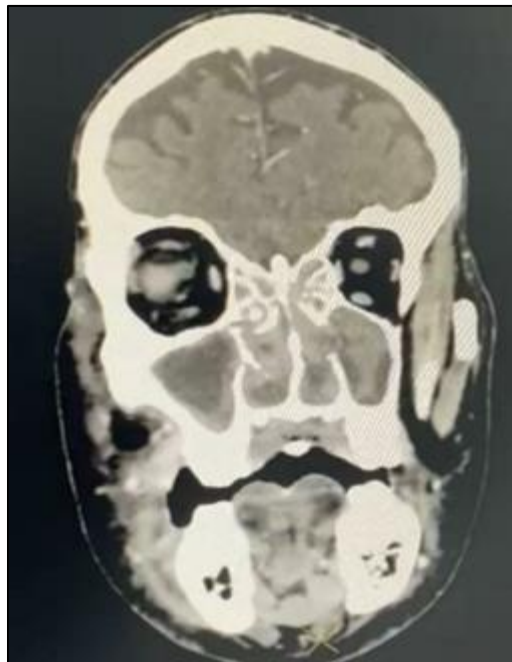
Coronal CT scann of the face passing by the nasosinus cavities
